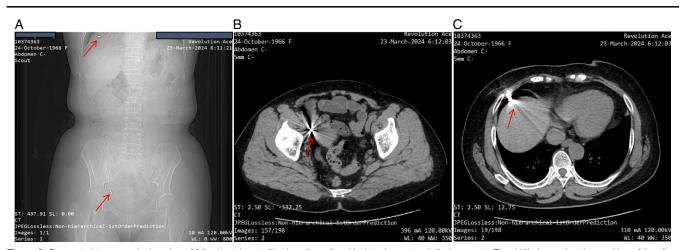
Computed tomography imaging of fallopian tube sterilization silver clip with detachment and displacement: Panel (A) shows that the position of the silver clip used for sterilization of the right fallopian tube is normal, while the left side has disappeared and moved to the upper right abdomen (red arrows). Panels (B) and (C) also clearly show a high-density metal shadow with strong metal artifacts at the right fallopian tube, while the left side has disappeared and is ectopic to the surface of the right liver and below its abdominal wall (red arrows).
